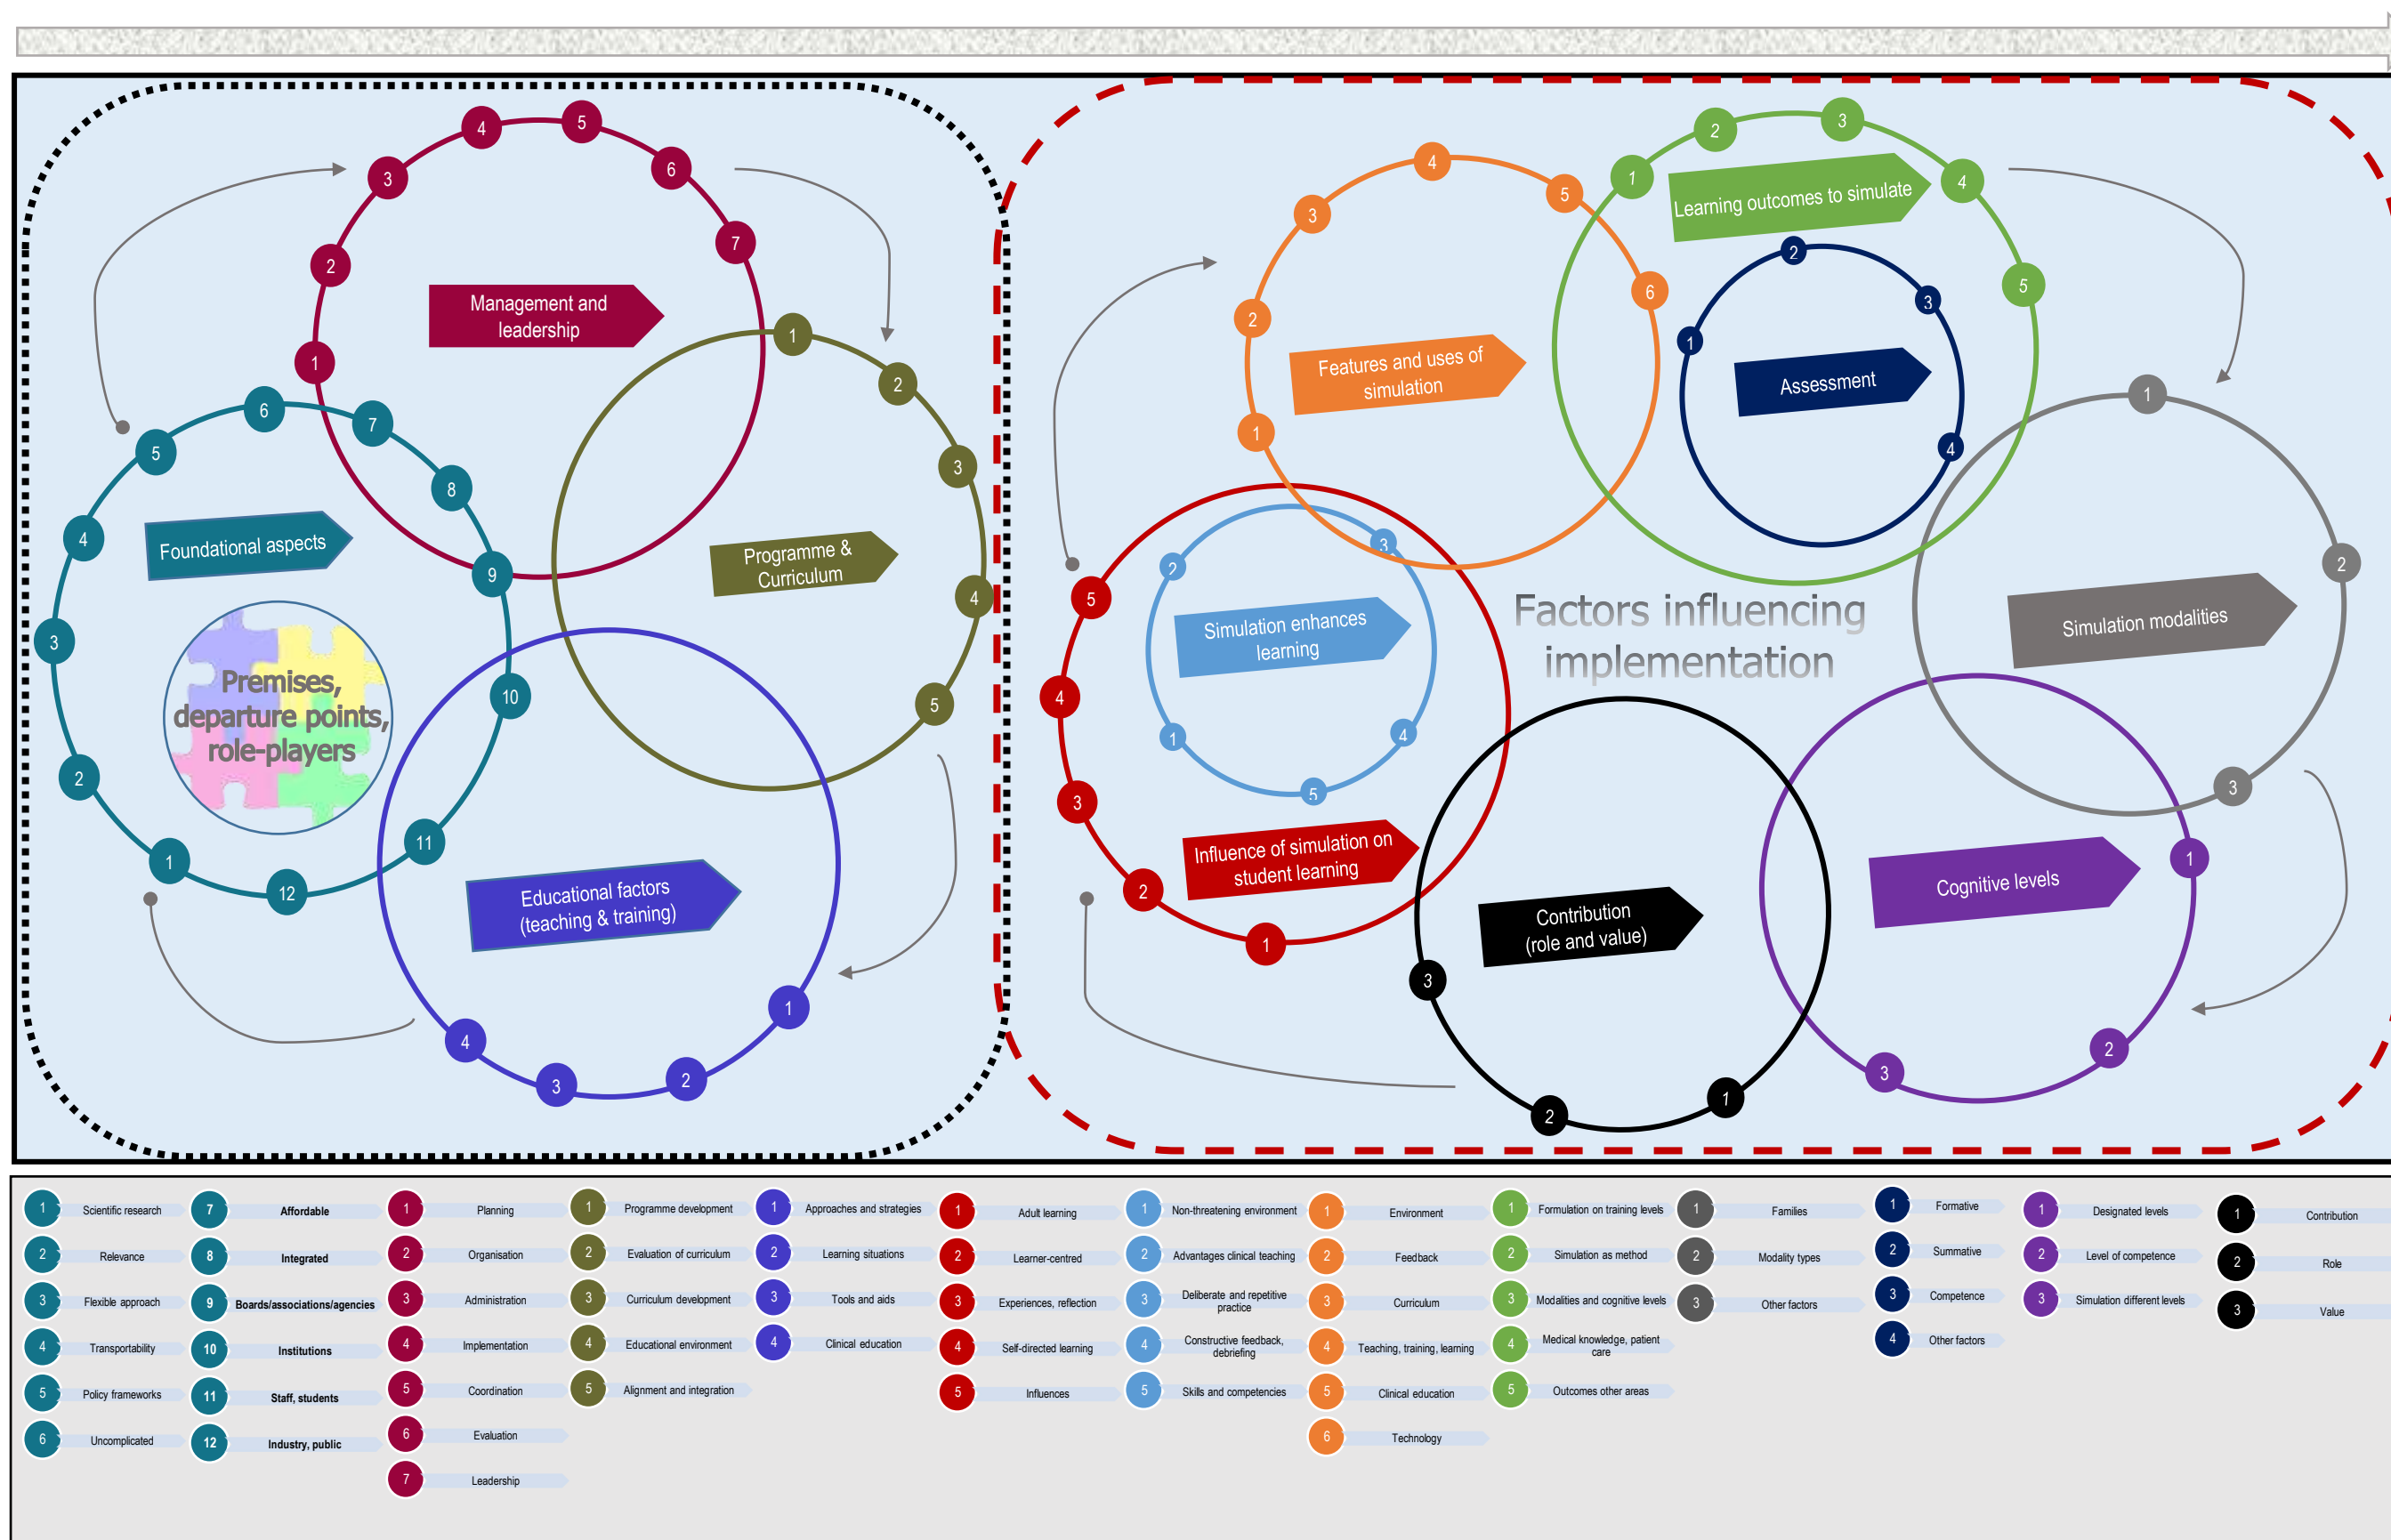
FOCUS AREAS AND ASPECTS THAT ARE ADDRESSED IN THE FRAMEWORK STRUCTURE
